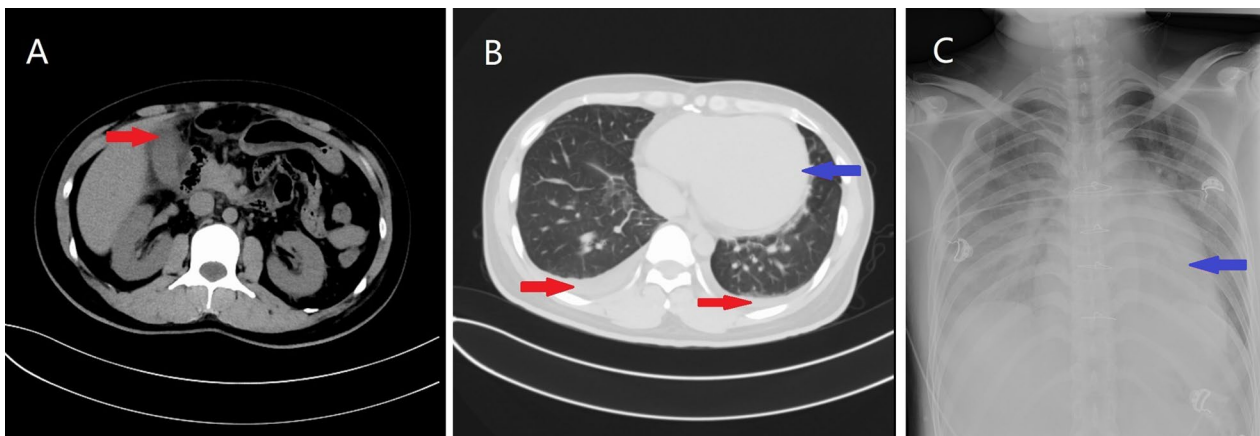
A Abdominal computed tomography imaging revealed pericholecystic effusion and thickening wall of the gallbladder (red arrow). B, C Cardiac enlargement (blue arrows), accompanied by bilateral minimal pleural effusion (red arrows)
